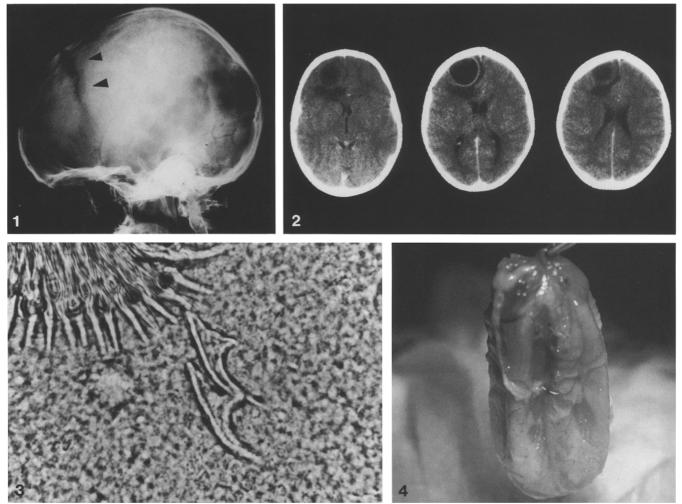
CT scan of a left frontal hydatid, showing a hypodense spherical cystic lesion with sharp demarcation, a small amount of perifocal edema, and compression of the left anterior horn
